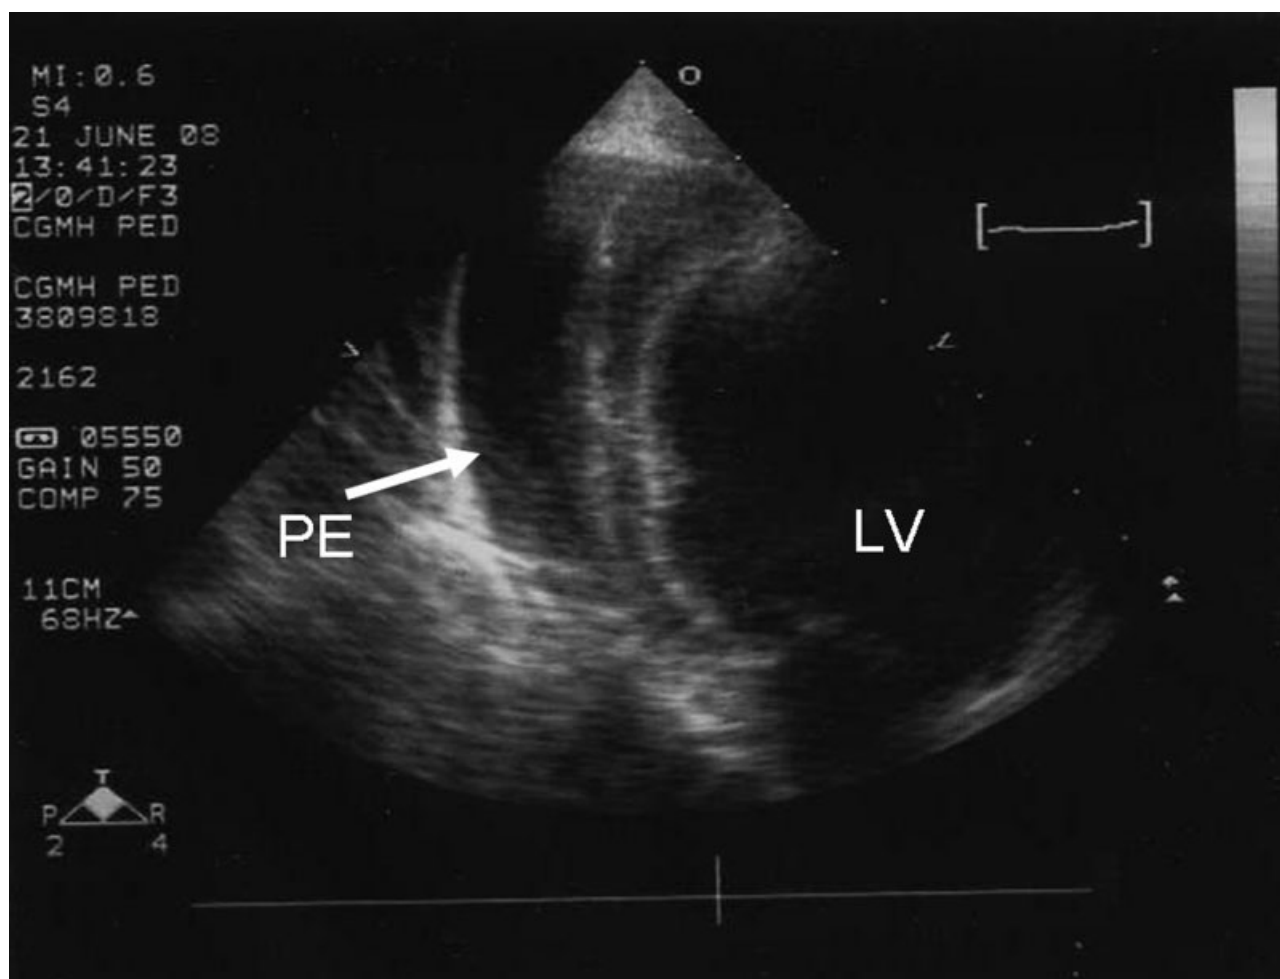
An echocardiogram obtained shortly after admission demonstrated a large circumferential pericardial effusion (PE, pericardial effusion, white arrow; LV, left ventricle).
